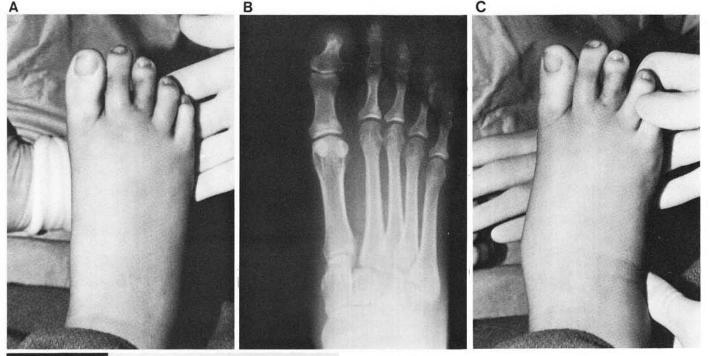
A. & B. Clinical and radiographic demonstration of Lisfranc injury Type C with marked edema and pathognomonic diastasis of first and second metatarsal. C. & D. Excessive motion is present clinically at the tarsometatarsal articulation. Abduction stress radiograph reveals gross dislocation
